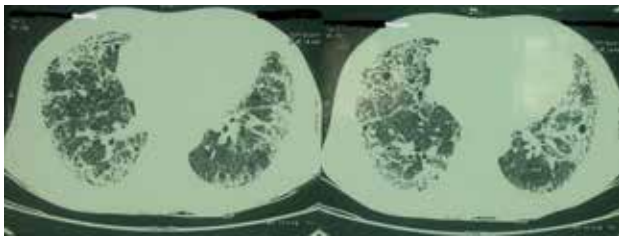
High resolution computed tomography of chest showing a diffuse parenchymal lung disease with "definite usual interstitial pneumonia" pattern.
